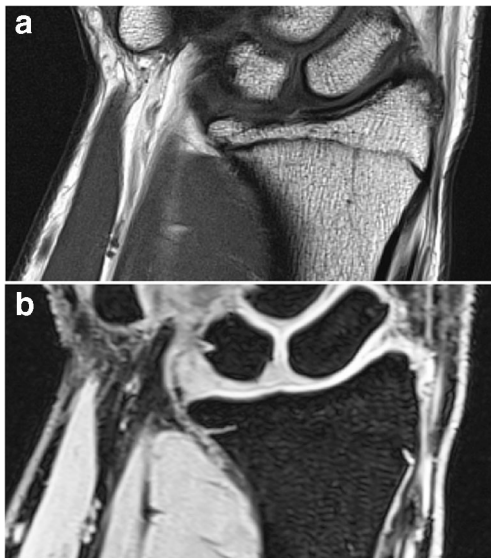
Coronal wrist MRI in a 17.9-year-old male. a T1-W spin-echo sequence shows partial bridging of the physal plate. Stage 3b was allocated. The chemical shift artifact causes a widened appearance of the remaining physal plate. b T1-W gradient echo volumetric interpolated breath-hold examination sequence shows more advanced bridging of the physal plate. Stage 3c was allocated. Fat suppression avoids the chemical shift artifact, causing a more tight delineation of the physal plate
